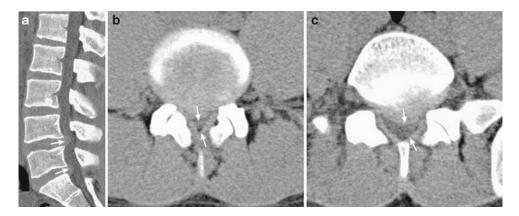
Lumbar spinal canal stenosis. A 38-year-old man presents with progressive lower limb pain and numbness brought on by standing and walking. Sagittal CT reconstruction (a) and axial CT images at L4 (b) and L5 (c) show a congenitally narrow central canal due to short pedicles with superimposed disk protrusions at L4 and L5
